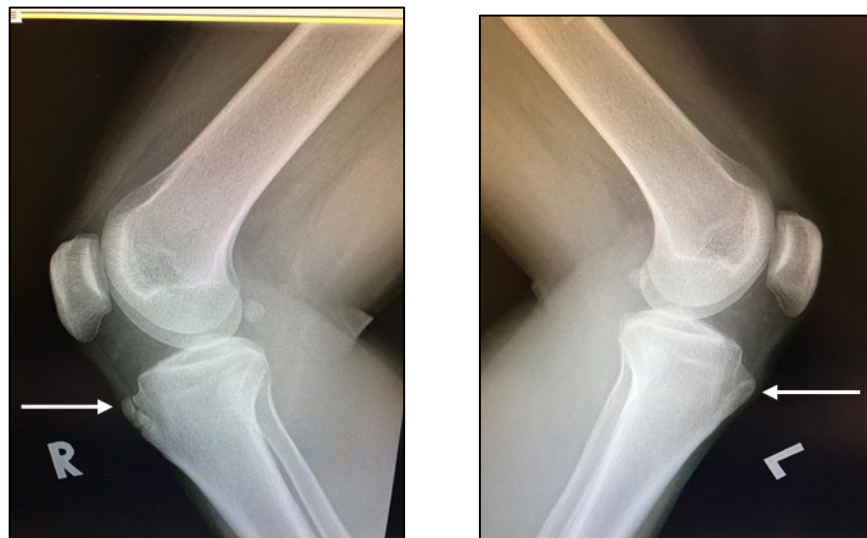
Plain radiographs of bilateral knee joints (lateral view) demonstrating fragmented apophysis of the right tibial tubercle and incomplete closure of the left tibial tubercle
